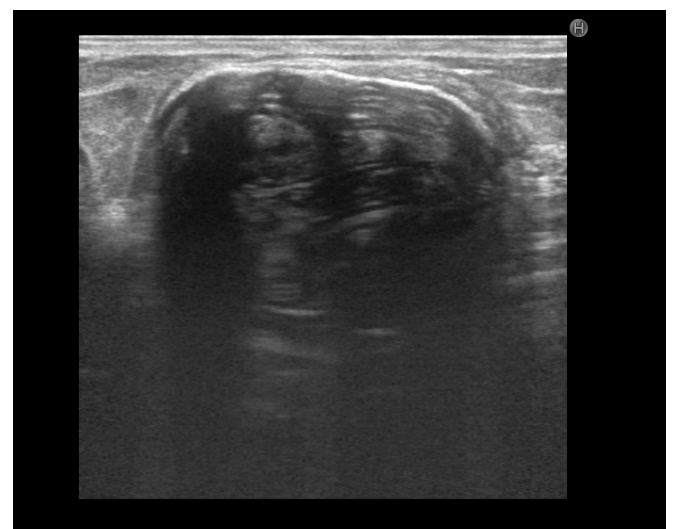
An ultrasound examination has identified a mass lesion characterized by a posterior shadow, which is likely due to calcification. The lesion displays a heterogeneous internal structure, featuring hypoechoic formations organized in circular lamellae, situated in the upper outer quadrant of the right breast.
